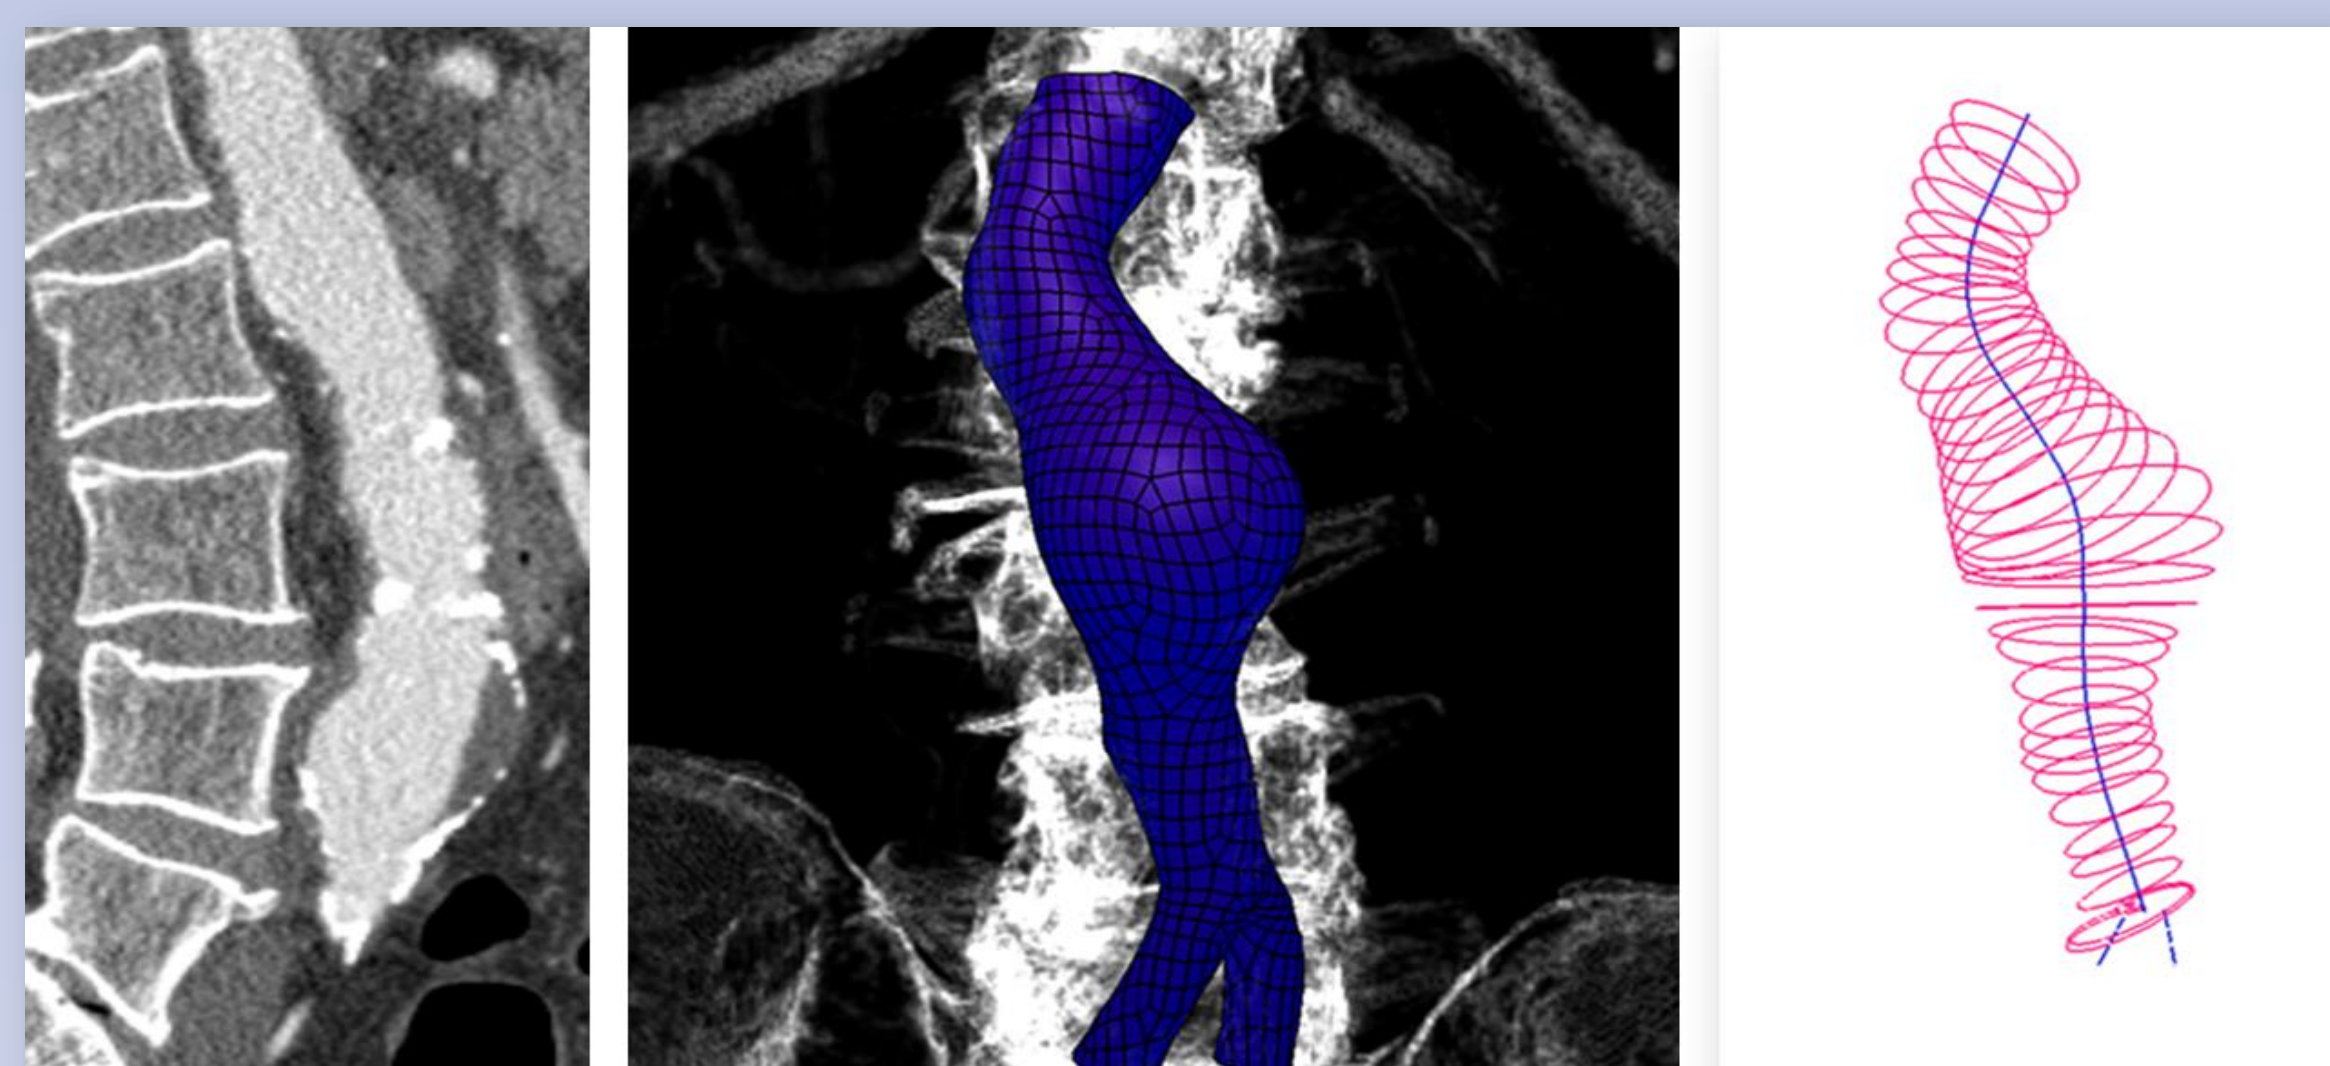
Derivation of the surrogate model to monitor the diameter expansion of an individual aneurysm. (Left) CT-A scan; (middle) Three-dimensional reconstruction; (right) cross-section based surrogate model that represents the wall geometry.
